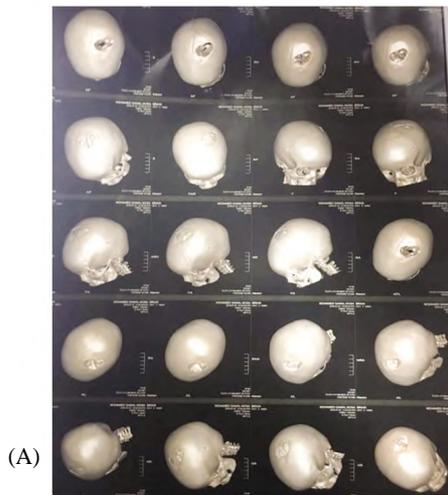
6 years old boy with history of compound depressed skull fracture operated upon by removal of comminuted fragments 6 months prior to admission (A) CT 3D reconstruction showing the skull defect (B) Intraoperative application of the construct (C) The patient at follow up after restoration of normal skull contour.
